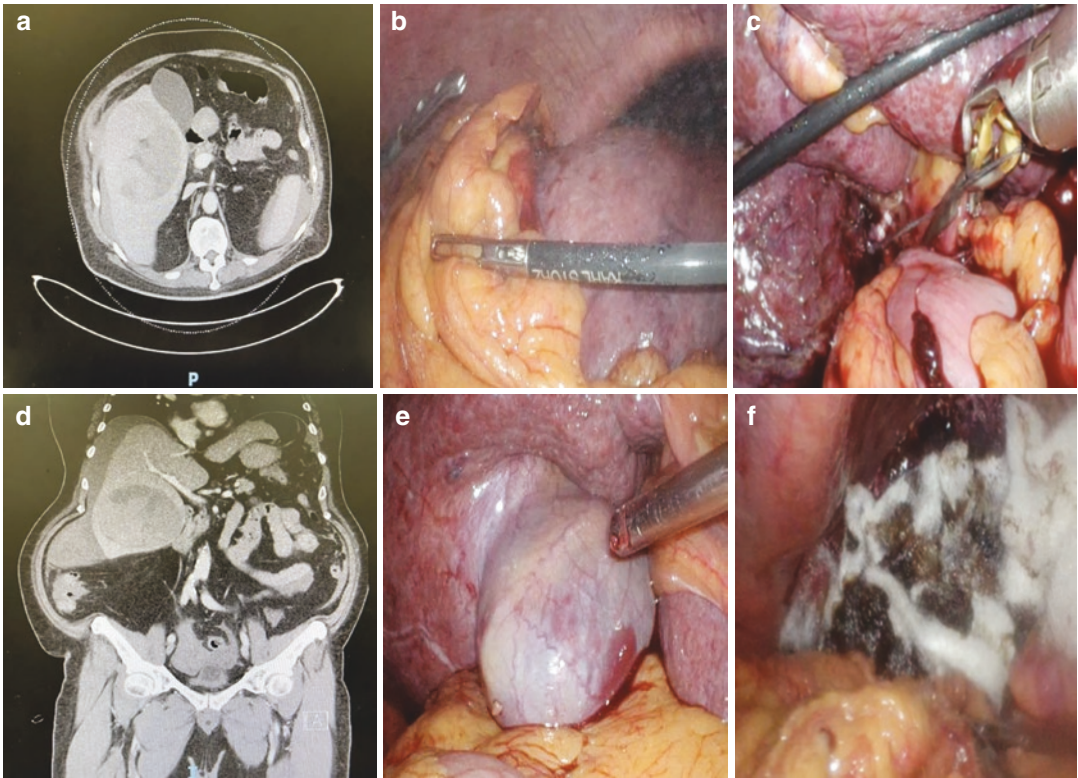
Laparoscopic anatomic resection of segment IV of a ruptured liver cancer in a 66-year-old male. Performed at Singapore General Hospital, Singapore. (a, b) Preoperative computed tomography scans of the patient in axial and coronal views respectively. (c) Displacement
